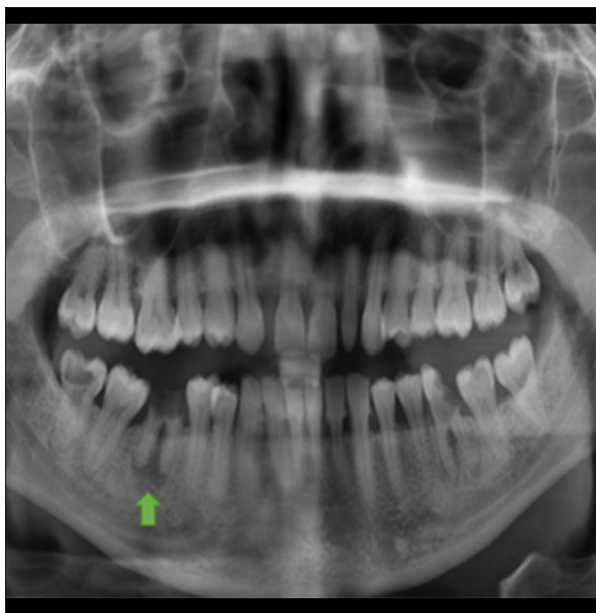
X-ray orthopantomogram. X-ray orthopantomogram showing lucency around the lower premolar root, consistent with the clinical suspicion of abscess formation (green arrow).
